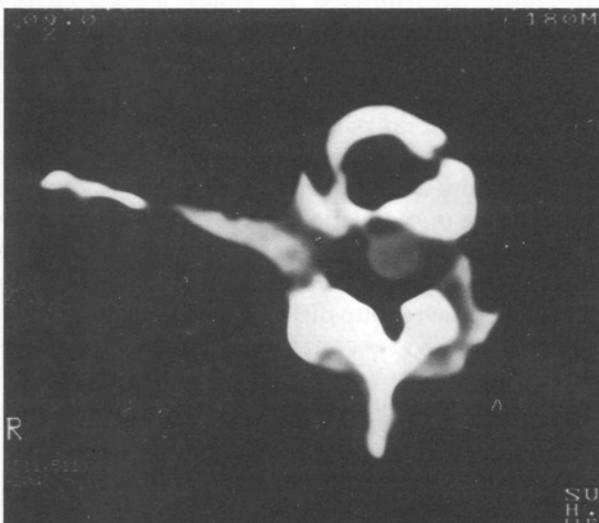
After 15 W, 2 s, 75+25 pulses(3,000 joules) of LN: A) half of the disc was vaporized on CT scan, B) a similar volume of vacuum phenomenon was observed with MR images.
